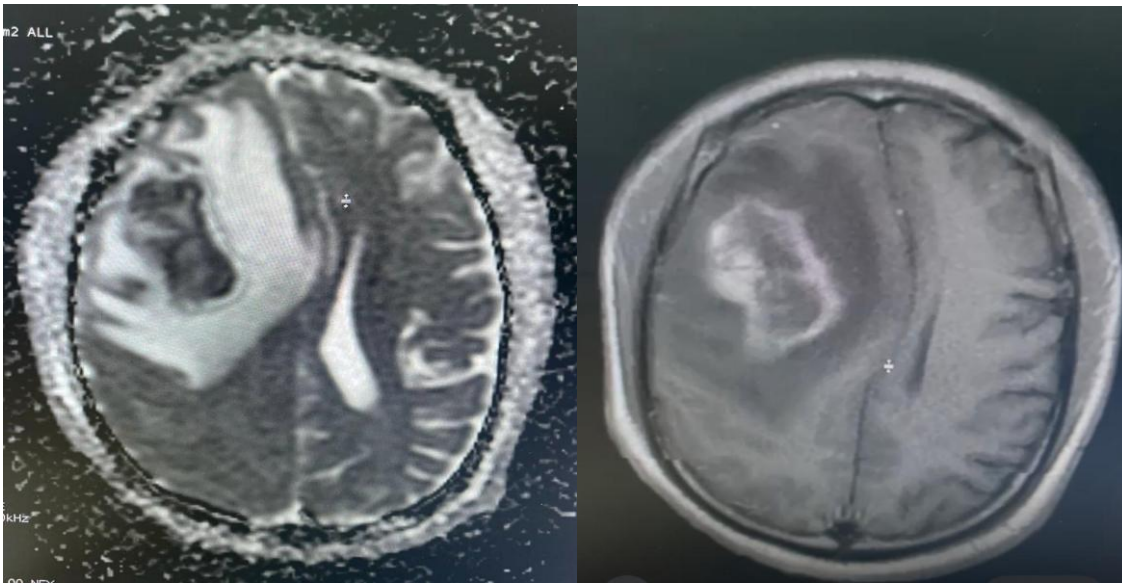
Brain MRI showing T2 and T1 contrast.
